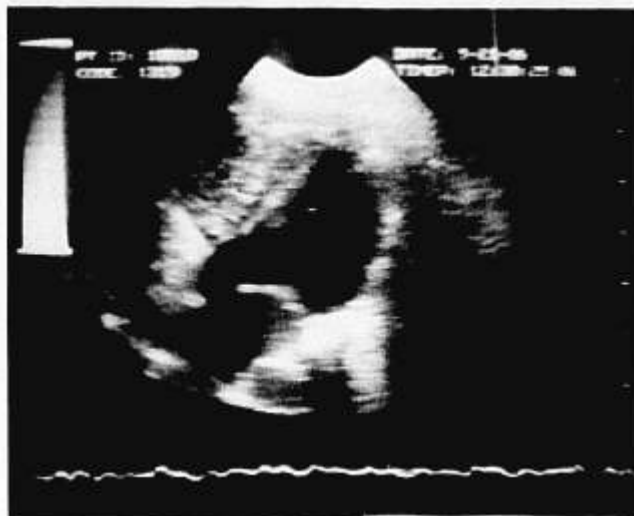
Contrast echocardiogram with stirred saline indicating a shunt at atrial level. The echoes rapidly entered the left ventricle from the left atrium. The four chamber picture shows contrast echoes from right atrium, right ventricle, and left ventricle.
